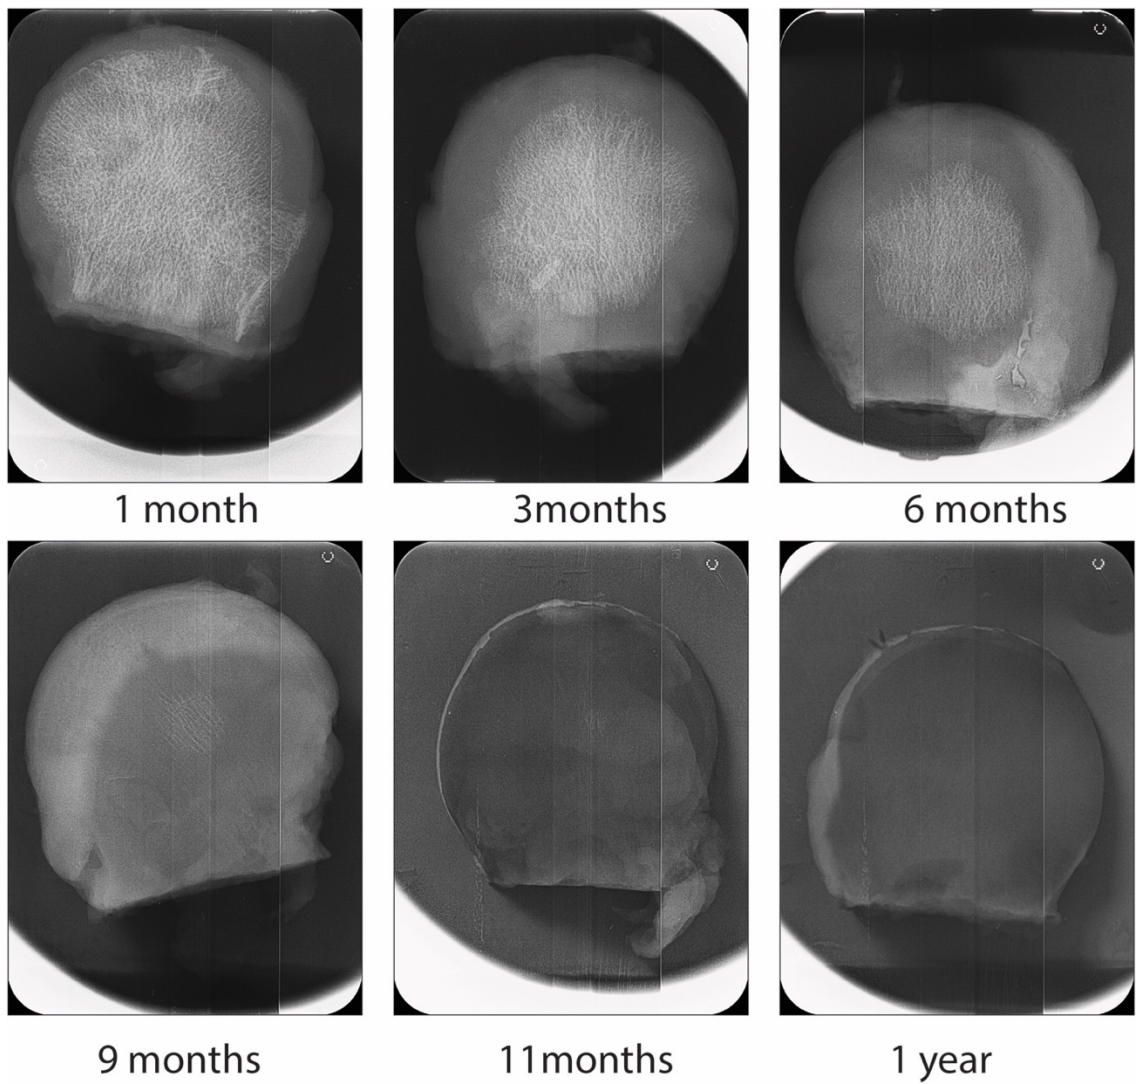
X-ray images showing gradual mineral removal by EDTA. The images were captured monthly on standard dental films and read on the automated unit. Gradual loss in mineral content can be visualised as the increase in opacity on the x-ray images.
